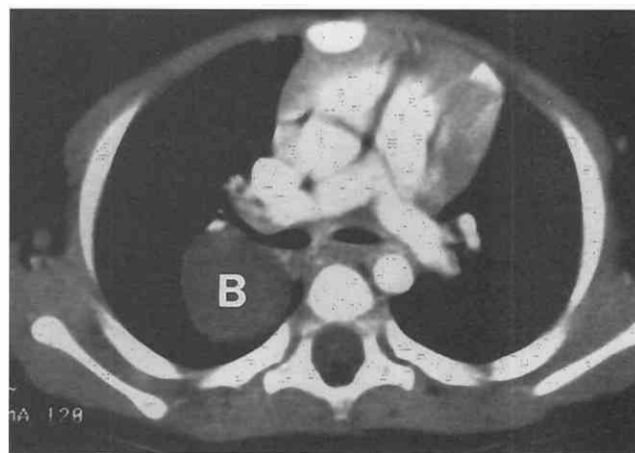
Bronchogenic cyst in a 10-month-old boy. CT scan shows well-defined, nonenhancing mass (B) within the right parahilar region.
